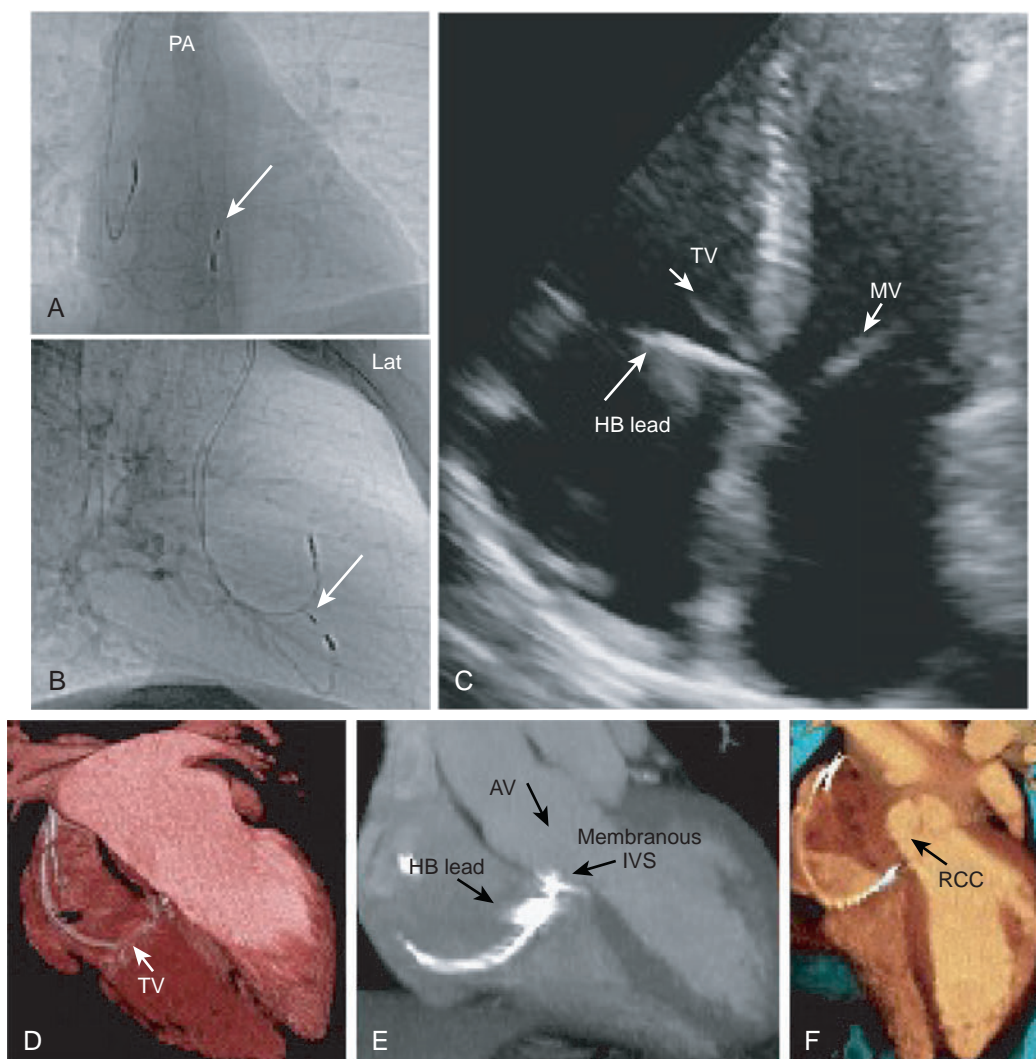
Location of Direct His Bundle (HB) Pacing Lead. Images from chest x-ray (A–B), transthoracic echocardiography (C), and cardiac computed tomography (D–F) showing the location of the direct HB pacing lead. Note that the electrode position is above the plane of the tricuspid valve (TV), in the supraventricular portion of the membranous septum below the level of right coronary cusp of the aortic valve. AV, Atrioventricular; CT, computed tomography; IVS, interventricular septum; Lat, lateral; MV, mitral valve; PA, postero-anterior; RCC, right coronary cusp. (From Vijayaraman P, Dandamudi G, Bauch T, Ellenbogen KA. Imaging evaluation of implantation site of permanent direct His bundle pacing lead. *Heart Rhythm*. 2014;11:529–530, with permission.)
